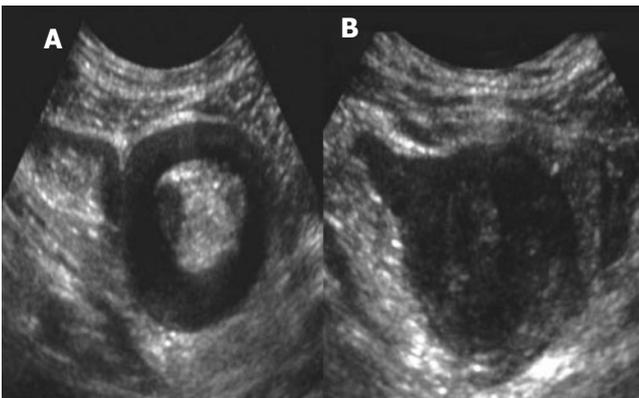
Abdominal ultrasound showed, A: "pseudo kidney sign" at the body of intussusception, B: Lobulated mass lesion at the head of intussusception, which was suspected of leading point of intussusception.
